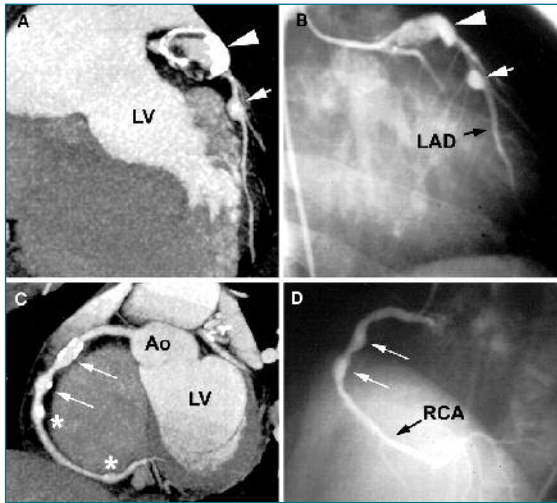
Multiplanar reconstructed CT image of the left anterior descending artery reveals a giant aneurysm (large arrowhead) with calcified wall (the eggshell-shaped high density area), thrombi (the low density area inside) and irregular residual lumen. A smaller aneurysm in the middle segment is also noted (small arrowhead). Angiography is presented adjacent to the CT images.
